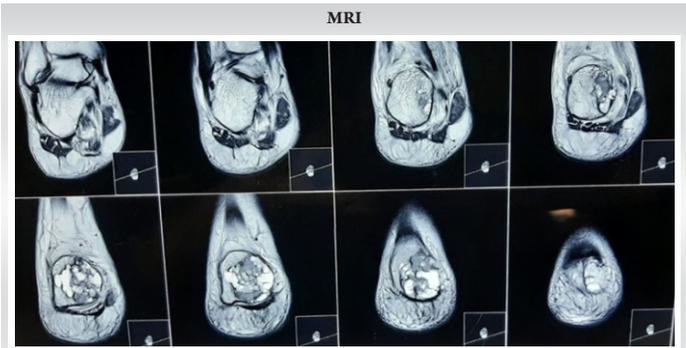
MRI of Right ankle showing lytic lesion with clearly defined borders
